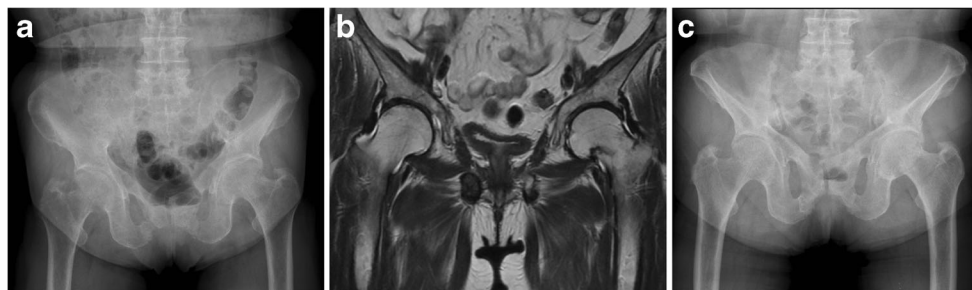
Neck fracture (case 7): a Anteroposterior radiograph of the hip at first presentation. The cortex of the femoral neck was thin with indistinct and hazy margins. b T1-weighted image of hips showing intermittent linear hypointense signals in the subcapital region at the left femoral head.
